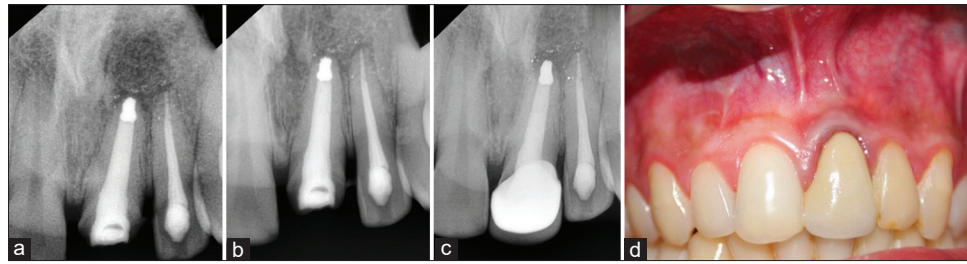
(a) Immediate radiograph postsurgery and placement of retrograde filling with respect to tooth #21. (b and c) Follow-up radiograph at 12 and 24 months' interval respectively (showing complete healing). (d) Clinical picture of completely healed surgical site and restoring the tooth #21 with porcelain fused-to-metal crown
